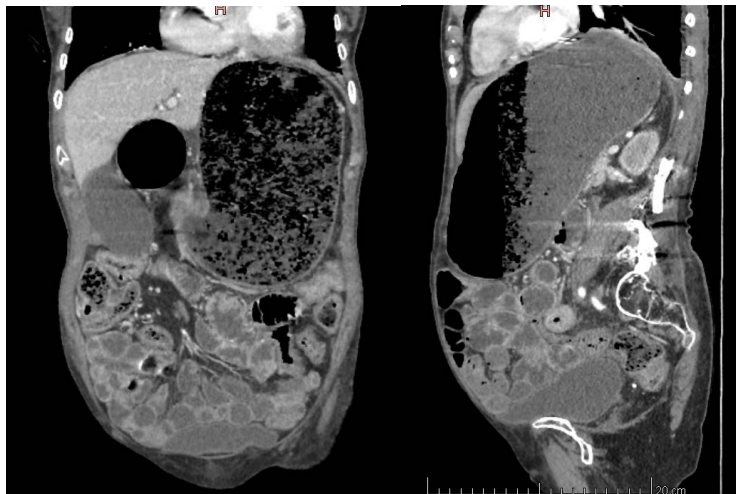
Contrasted computed tomography showing gallbladder dilatation and gastromegaly.
